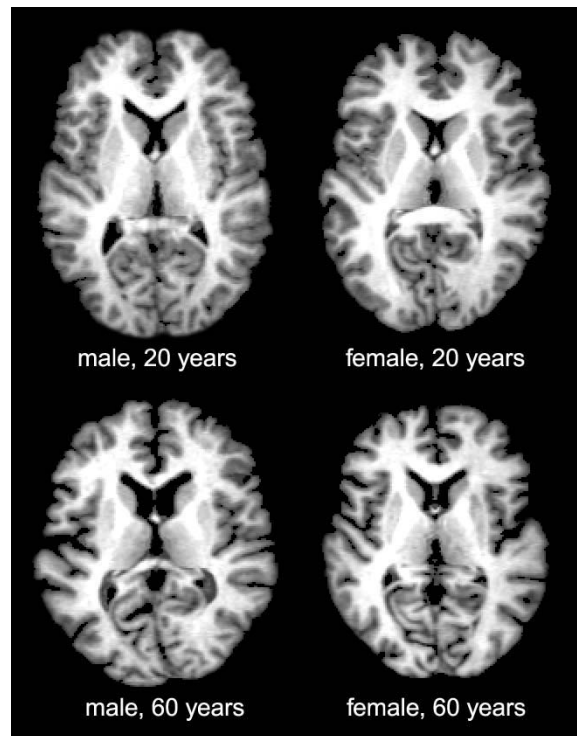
Example slices of MRI-T1 brain images of young and aged subjects.
